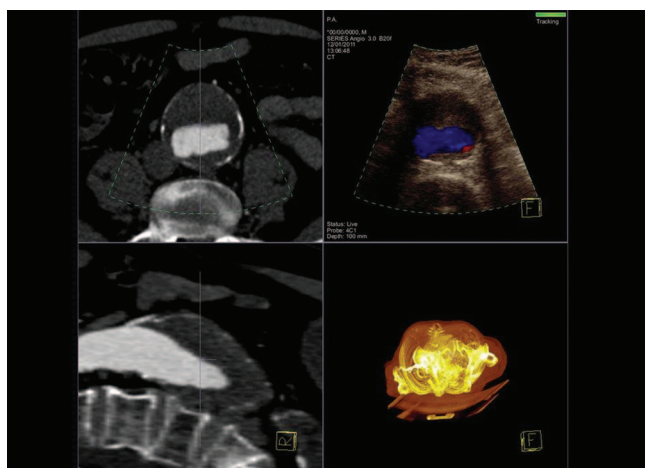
Example of CT/US image fusion during preoperative evaluation of a patient with an abdominal aortic aneurysm. The patient had already experienced a thin-section contrast-enhanced CT scan. The patient-specific volumetric CT dataset was loaded into the ultrasound unit and the interlocking of cross-sectional CT images with corresponding real-time US images (image registration) was automatically performed in a few seconds by proprietary software-embedded without human interaction or external fiducial placement. The image registration process automatically updates and recalibrates the coregistered data to adjust for patient movement when necessary. The operator performs a transabdominal ultrasound scan of the aortic aneurysm in color Doppler mode (top right: sonography image with blood flow within the aneurysm) and the software updates and portrays the corresponding matched CT image in real-time and on the same screen (top left: corresponding axial contrast-enhanced CT image). As the operator scans the patient, further reconstructed CT views are provided for reference and orientation. (Bottom left: reconstructed midline sagittal CT image of the aneurysm shows the scanning level, bottom right: volume rendered image reconstruction of the imaged body segments; the chest and abdomen in this occasion) Innovations such as this may allow for exploitation of baseline CT scans with high anatomical detail during ultrasound-guided interventions, such as, during real-time ultrasound-guided puncture of the aneurysmal sac in order to treat an ongoing endoleak. Image courtesy of Siemens Healthcare, Germany (The eSie® image fusion platform; reproduced with permission).
